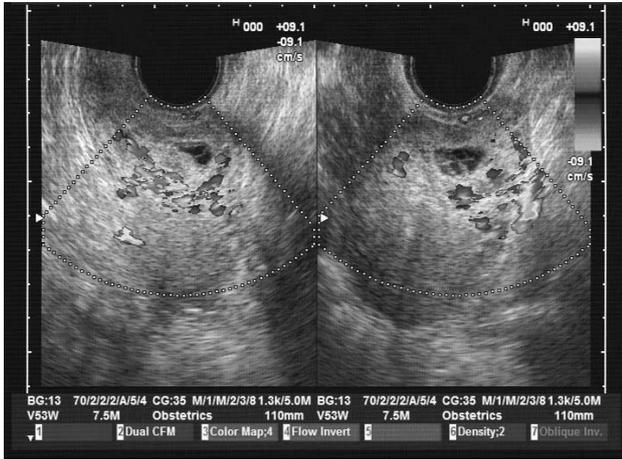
Endovaginal sonography of the gestational sac in the anterior part of the uterine isthmus, just located in the previous cesarean section scar. CDFI shows rich blood flow signals surrounding the gestational sac and the sac edge is only two to three mm from the uterine serosa.
